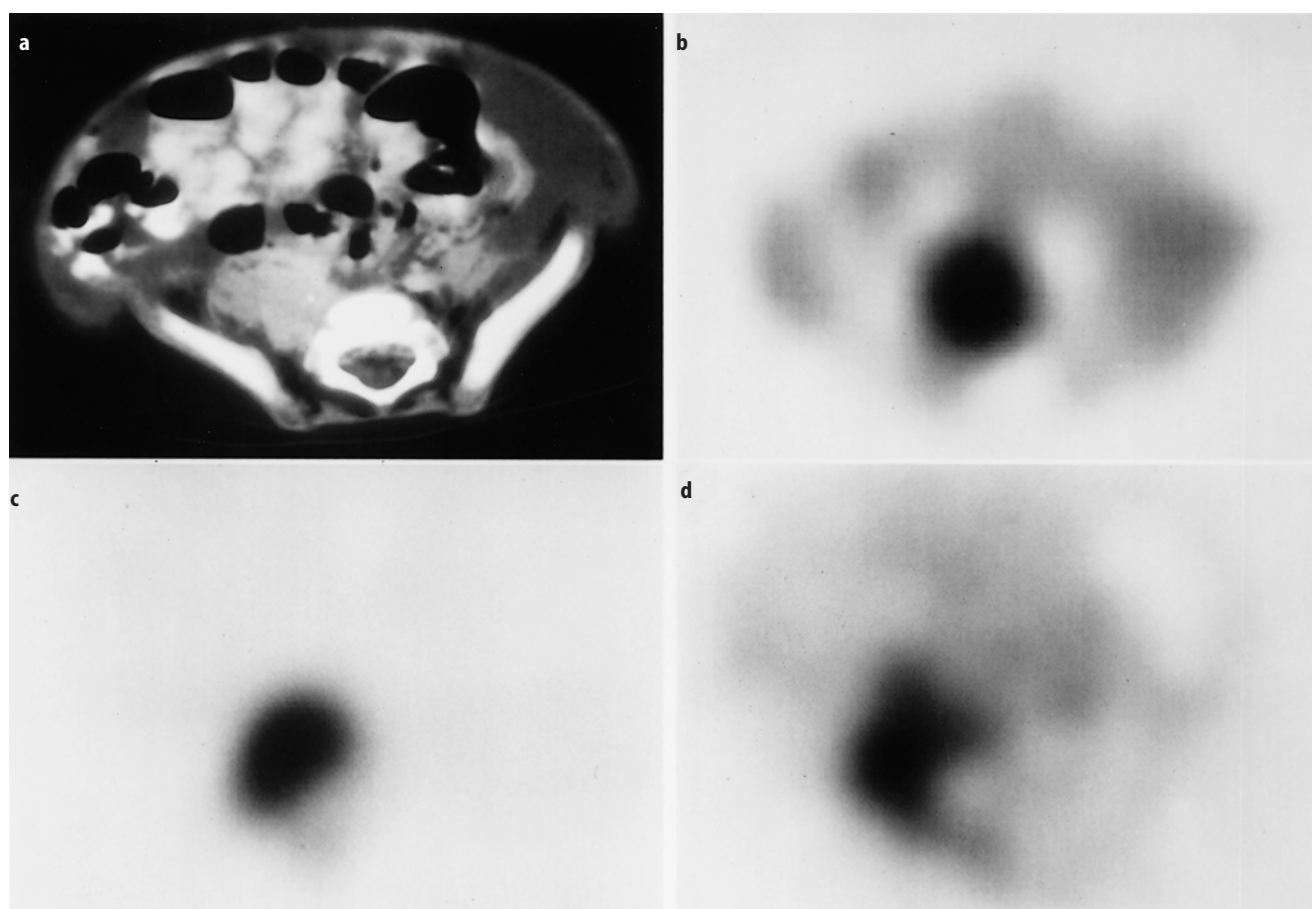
(a) CT scan of the pelvis of a 6-month-old boy following surgical debulking of abdominal–pelvic neuroblastoma. There is abnormal soft tissue with speckled calcification in the right posterior pelvis. (b) MIBG-SPECT scan at 24 h shows uptake into the tumor. (c) ^{11}C -Hydroxyephedrine (HED)-PET scan at 20 min following injection. There is excellent uptake within the neuroblastoma, and the image appears similar to the MIBG-SPECT examination. (d) FDG-PET scan at 50 min shows moderate accumulation of FDG within the mass relative to surrounding background. However, the tumor appears better delineated with the more specific adrenergic tumor imaging agent HED. (Reprinted by permission of the Society of Nuclear Medicine from Shulkin BL, Wieland DM, Baro ME, et al. PET hydroxyephedrine imaging of neuroblastoma. *J Nucl Med* 1996;37:18, Figure 2.)
